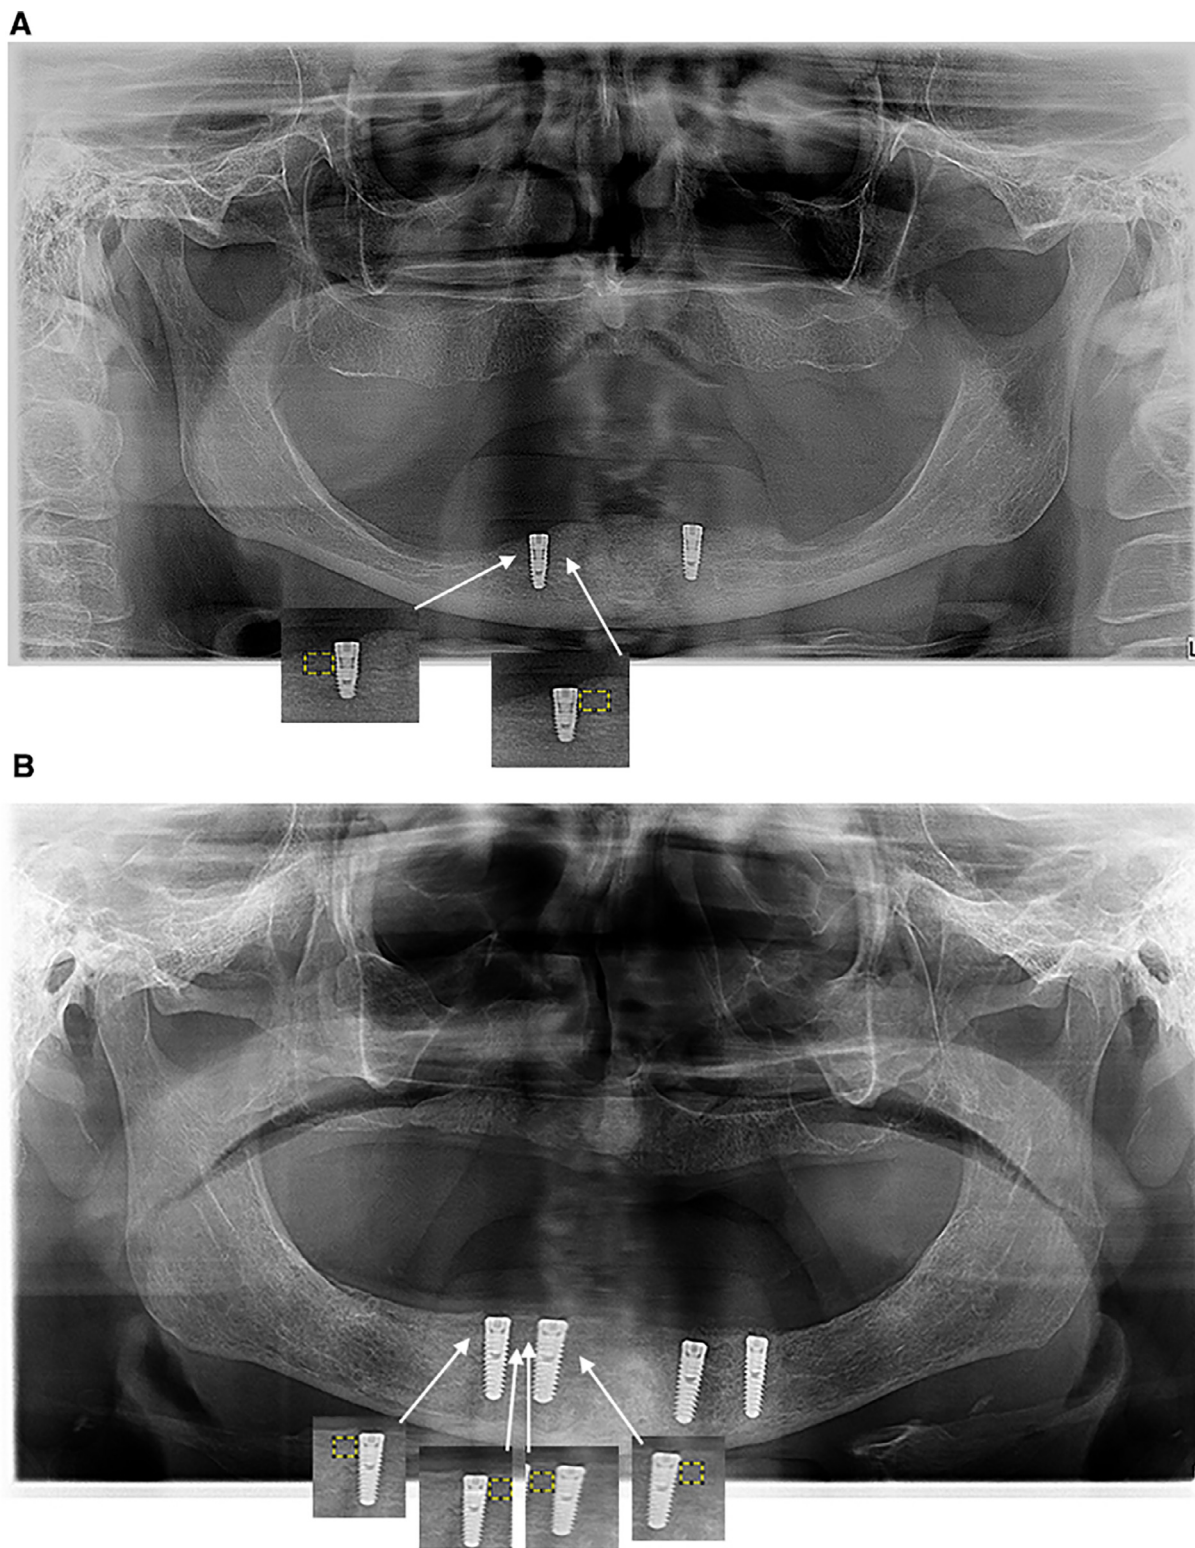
Panoramic radiographs of 2-implant (A) and 4-implant (B)—supported overdenture prostheses. The inserts demonstrate the 2 regions of interest (ROIs), on the mesial and distal sides of each implant examined for fractal analysis.
